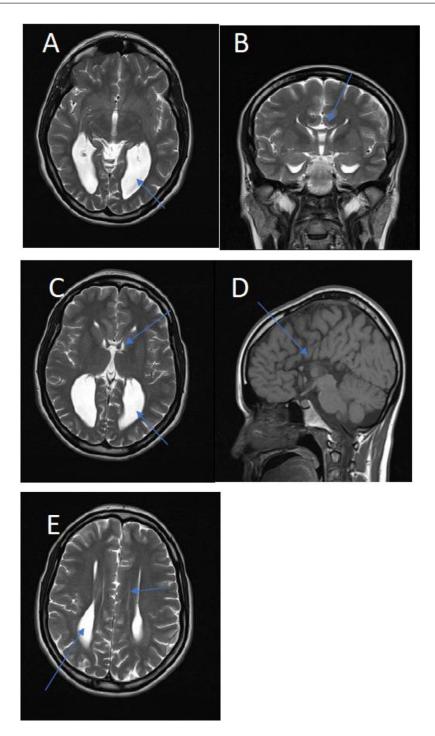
(A) Axial T2 brain MRI sequence with dilatation of the occipital horns of the lateral ventricles (colpocephally). (B) Coronal T2 sequence brain MRI with moose head sign in the lateral and third ventricles. (C) Axial T2 brain MRI sequence with racing car sign of the lateral ventricles. (D) Sagittal T1 brain MRI sequence with complete corpus callosum agenesis (CCA) and radiating midline sulci. (E) Axial T2 sequence brain MRI with tear drop lateral ventricles (long arrow) and Probst bundles (short arrow).
